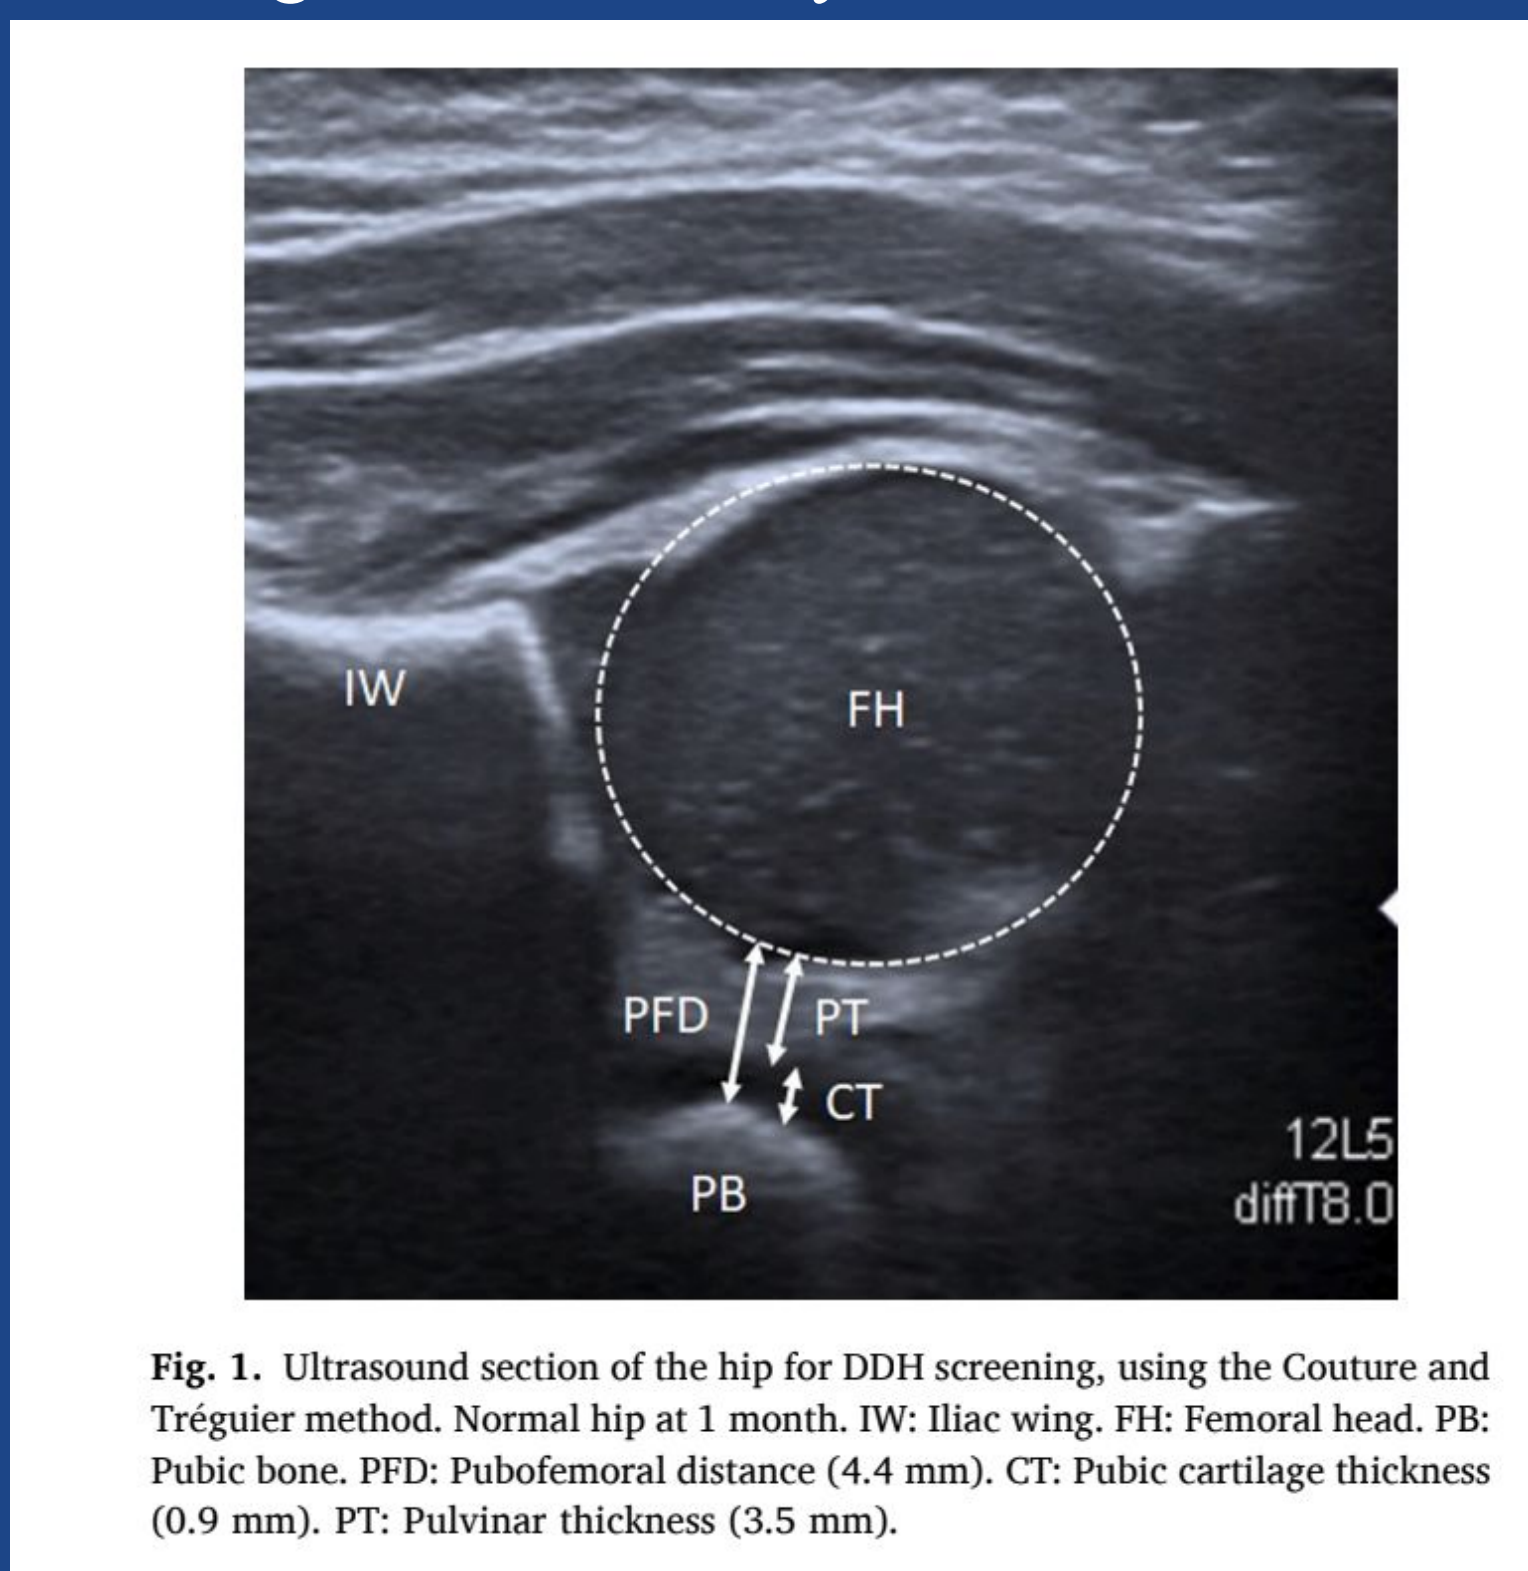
Ultrasound section of the hip for DDH screening, using the Couture and Tréguier method. Normal hip at 1 month. IW: Iliac wing, FH: Femoral head, PB: Pubic bone, PFD: Pubofemoral distance (4.4 mm), CT: Pubic cartilage thickness (0.9 mm), PT: Pulvinar thickness (3.5 mm).
